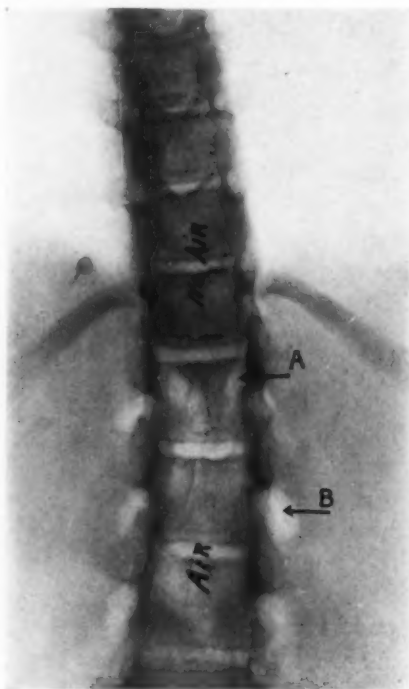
X-ray photograph (not retouched) showing the localization of a spinal cord tumor after injection of air. Arrow A shows the conical shadow of the tumor situated in the lumbar enlargement; arrow B shows dilated pouch of a spinal nerve resulting from the increased pressure of hydrocephalus. It will be noted that the entire vertebral column below arrow A is light, owing to the presence of air. For two vertebræ above the air shadow it is dense because there is a tumor and no air. Above the tumor zone the inter-laminal spaces show, though far less distinctly than the air column below the tumor. It will be noted that there are three pouches at the entrance of the spinal nerves on the left, and four on the right—the fourth being opposite the tumor and is, of course, in continuity with the column of air below the tumor.
